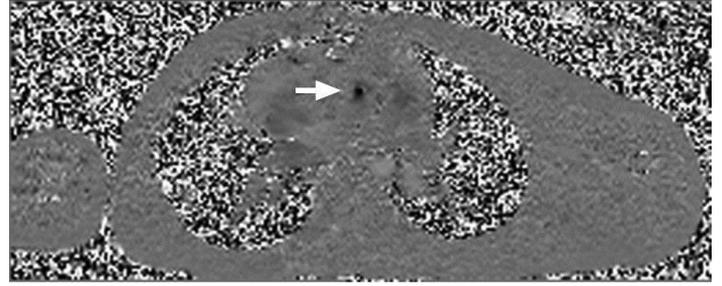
5-year-old female post truncus arteriosus repair and quadricuspid aortic valve. Right ventricular outflow tract (RVOT) projection image of cardiac MRI obtained on a Siemens TimTrio 3.0T scanner using a cine FLASH sequence (TR/TE/flip angle: 36.8ms/1.8ms/0°) demonstrates regurgitant jet across the aortic valve into the left ventricular outflow tract (arrow), indicating aortic valve regurgitation (32% regurgitant fraction per software based quantitative analysis).
